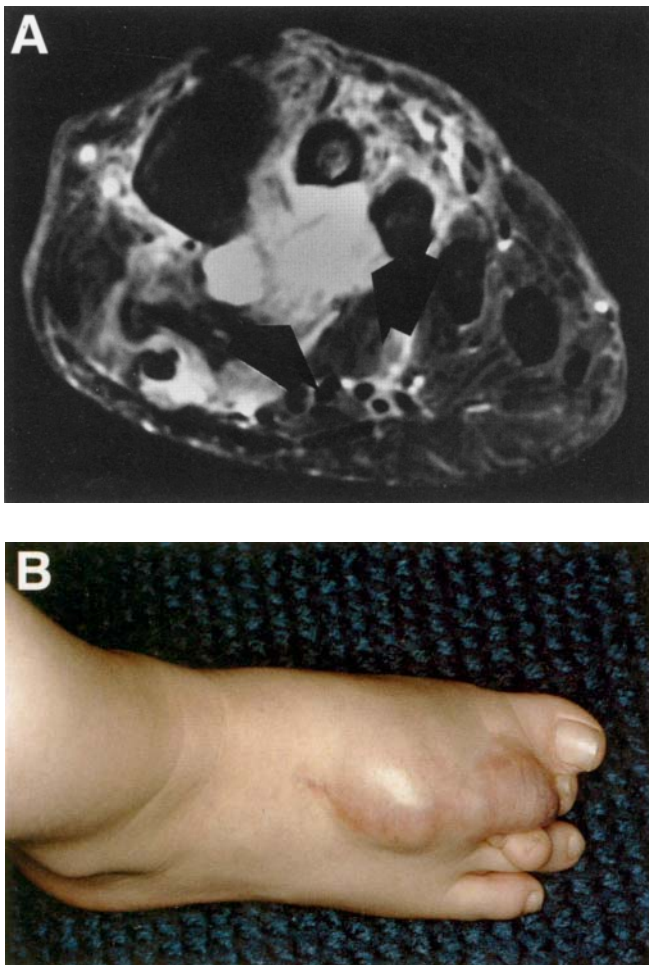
(A) T2-weighted magnetic resonance image of the foot, showing extensive high-grade malignant fibrous histiocytoma (MFH) (arrows) of almost the entire plantar aspect of the foot. Extension to the dorsal aspect of the foot is noted. (B) Extensive high-grade angiosarcoma of the dorsal aspect of the foot.
